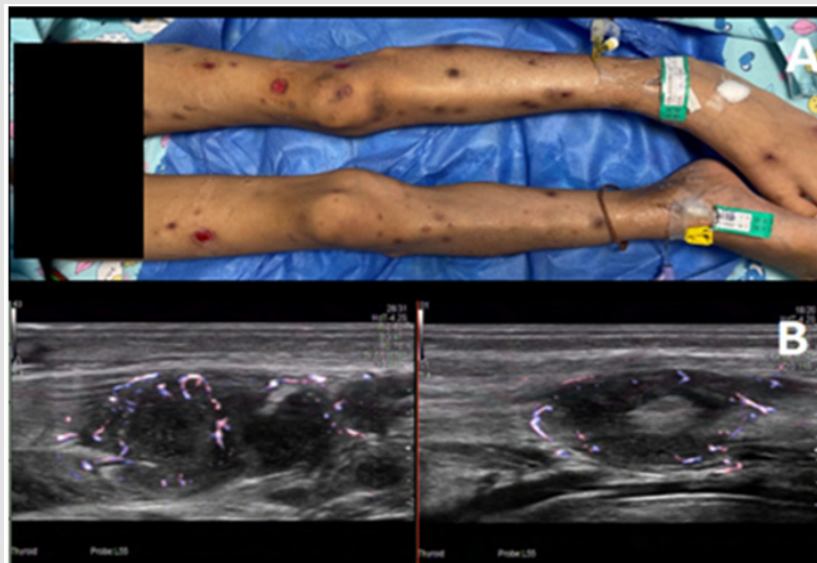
Skin lesions and B-ultrasound images of both lower extremities.
